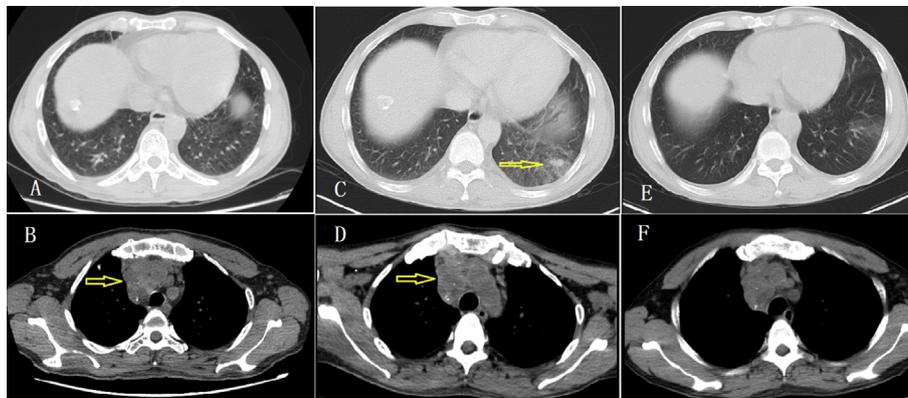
Chest high-resolution computed tomography revealing exudate disseminated throughout both lung fields, especially in the lower lung (Fig. 1A and B). Lung lesions with multiple enlarged and calcified mediastinal lymph nodes, and disseminated exudate throughout the left lower lobe (Fig. 1C and D). Post-treatment chest HRCT showed that the lesions were completely resorbed after antifungal treatment. (Fig. 1E and F).
